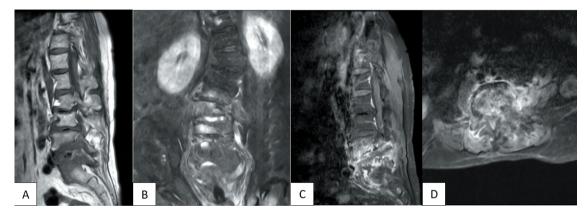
A 65-year-old female patient with pyogenic spondylodiscitis. A.T1-weighted sagittal image shows hypointensity in vertebrae L4-S1 and the L5-S1 intervertebral disc. B. STIR coronal image reveals hyperintensity in the affected vertebrae and intervertebral discs. C, D. Post-contrast T1-weighted images show diffuse enhancement of the L4-S1 vertebral bodies and the L5-S1 intervertebral disc, with extensive spread to the surrounding soft tissues, forming epidural and soft tissue abscesses with thick, irregular walls.
